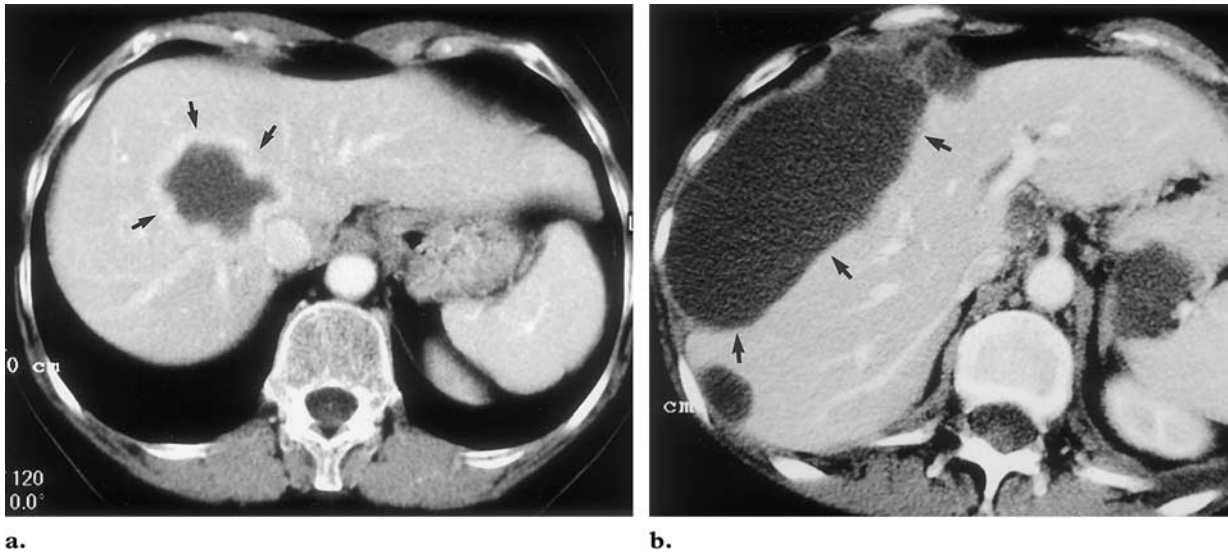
Cystic metastases. (a) Portal-venous-phase contrast-enhanced CT scan obtained in a 42-year-old woman with metastatic breast carcinoma shows a cystic lesion with peripheral enhancement (arrows). (b) Portal-venous-phase contrast-enhanced CT scan obtained in a 57-year-old woman shows a 7-cm-diameter elliptical cystic lesion (arrows) on the surface of the liver. This lesion proved to be metastatic ovarian cancer.
